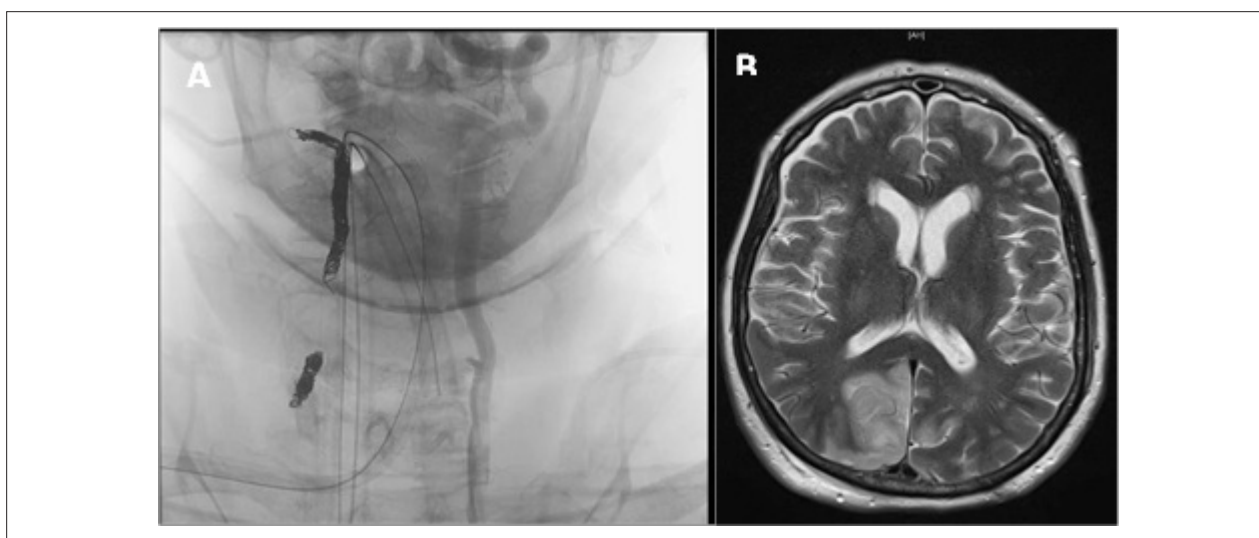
(A) Proximal and distal right vertebral artery coil embolization. (B) MRI demonstrating multiple infarcts.
